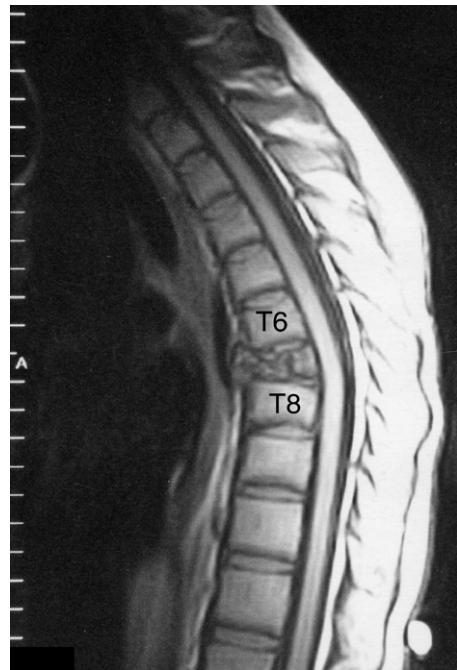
Thoracic spine MRI sagittal T1-weighted image showing the wedge compression fracture of the T7 body with localized kyphosis at this level and effacement of the dural tube. Note the kyphosis that has developed in the thoracic spine due to the T7 compression fracture.
